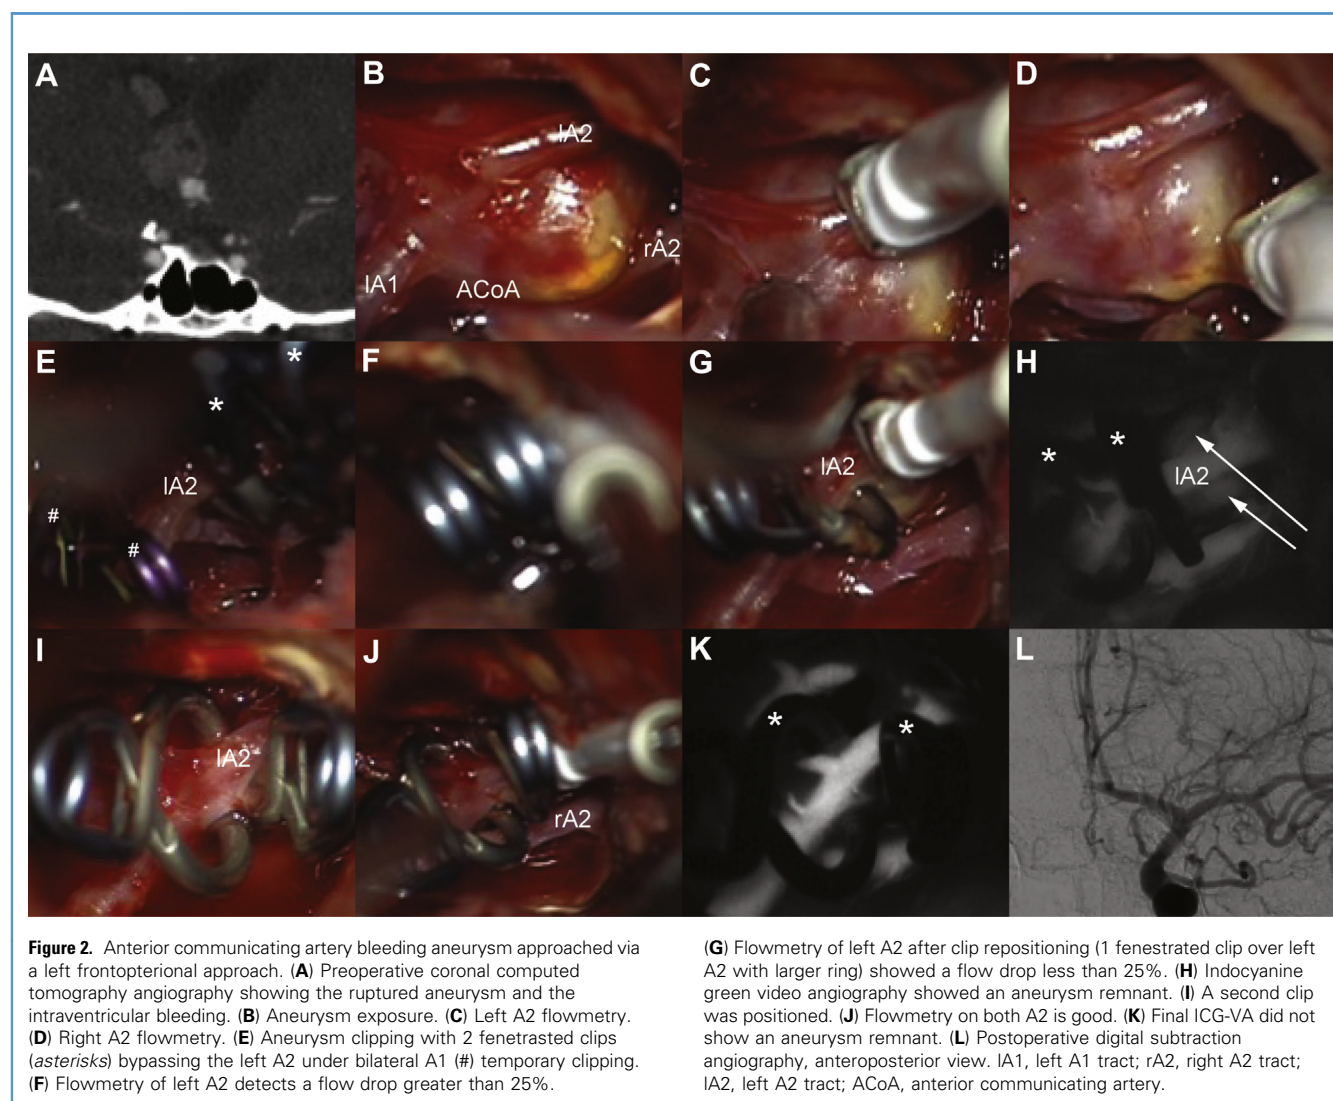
Anterior communicating artery bleeding aneurysm approached via a left frontopterional approach. (A) Preoperative coronal computed tomography angiography showing the ruptured aneurysm and the intraventricular bleeding. (B) Aneurysm exposure. (C) Left A2 flowmetry. (D) Right A2 flowmetry. (E) Aneurysm clipping with 2 fenestrated clips (asterisks) bypassing the left A2 under bilateral A1 (#) temporary clipping. (F) Flowmetry of left A2 detects a flow drop greater than 25%.
